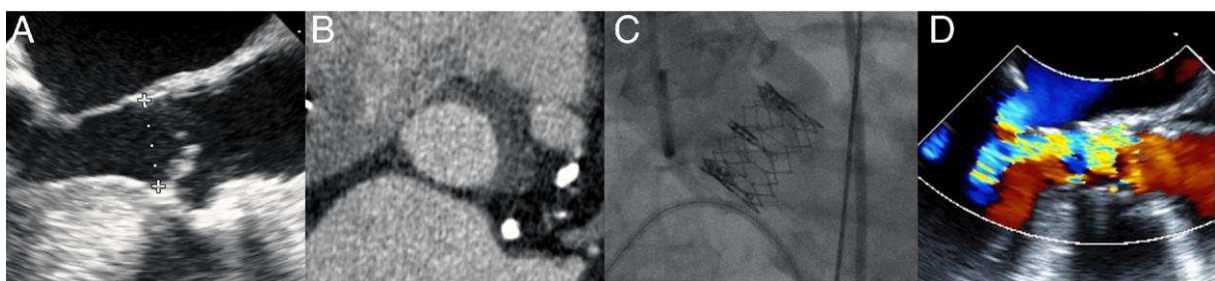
In a 82 year old patient, a 23-mm Sapien XT (Edwards Lifesciences, Irvine, California) valve was selected based on a TEE annular diameter of 22 mm (A). The MDCT mean annular diameter was 25 mm (22 x 28 mm) and area 4.90 cm². The THV was undersized by 2 mm relative to the mean diameter and by 15% relative to the annular area (B). The THV appeared undersized on aortic root angiography (C). The patient had moderate to severe paravalvular regurgitation on echocardiography (D).
